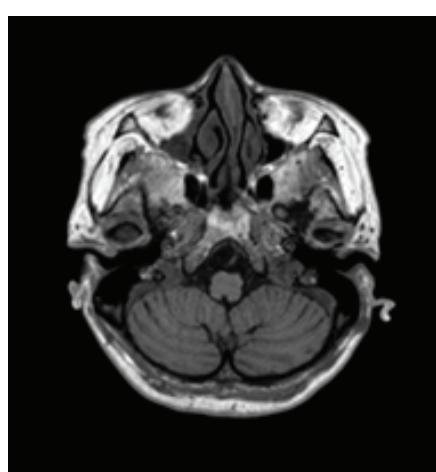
MRI picture of isolated cerebellar atrophy
